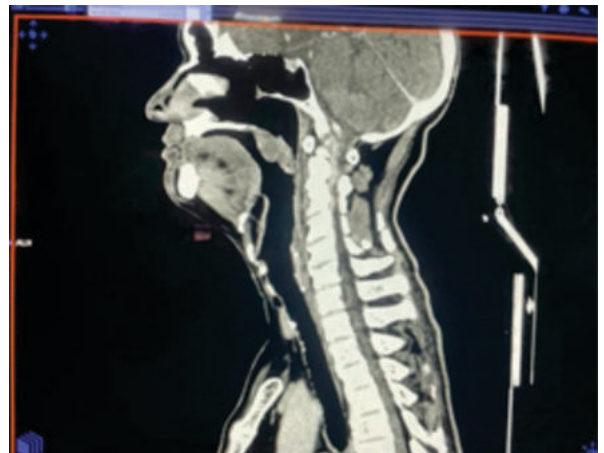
CT Image Of Nasopharyngeal Tumour
